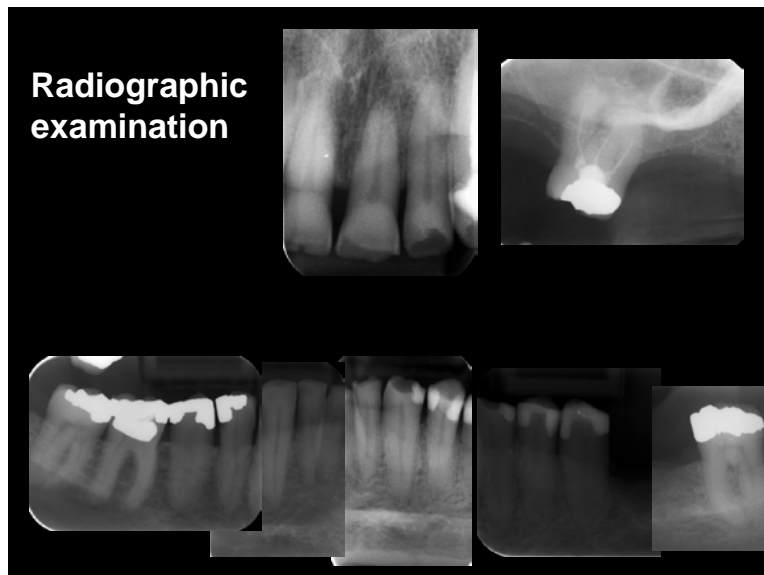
The radiographs possible to achieve, did not reveal any pathological condition. Because the fear of triggering pain when placing intra-oral film, an OPG is planned at the next recall.
